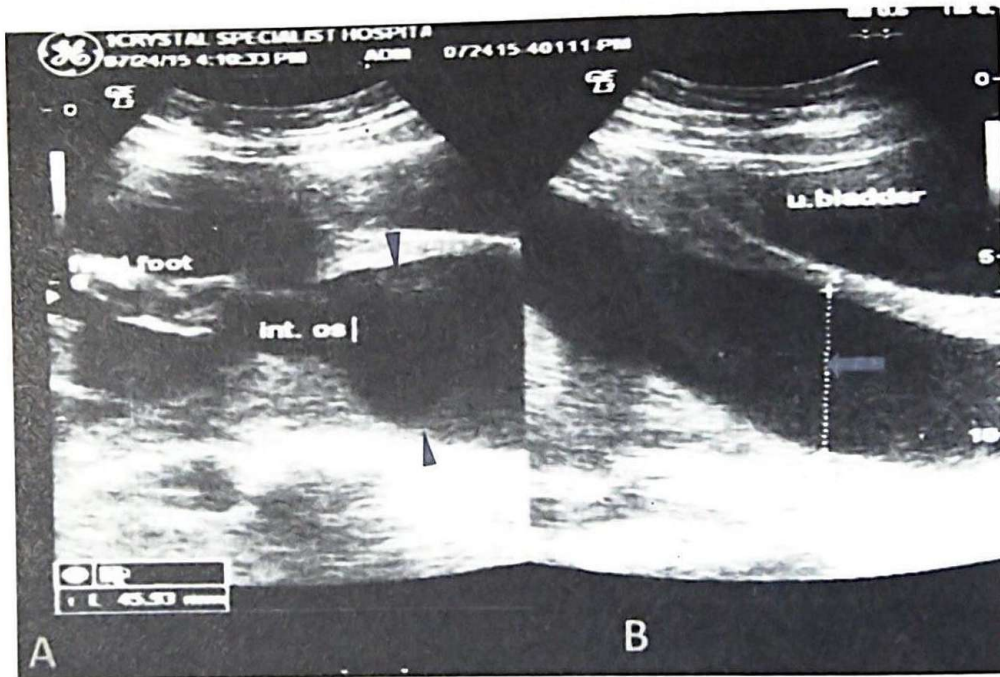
Sonogram showing incompetent cervix. A. Observe the opened internal Os with the protruding foetal foot and the funnelling of the cervix (arrowheads). B. Observe the widened cervical diameter (block arrow).
